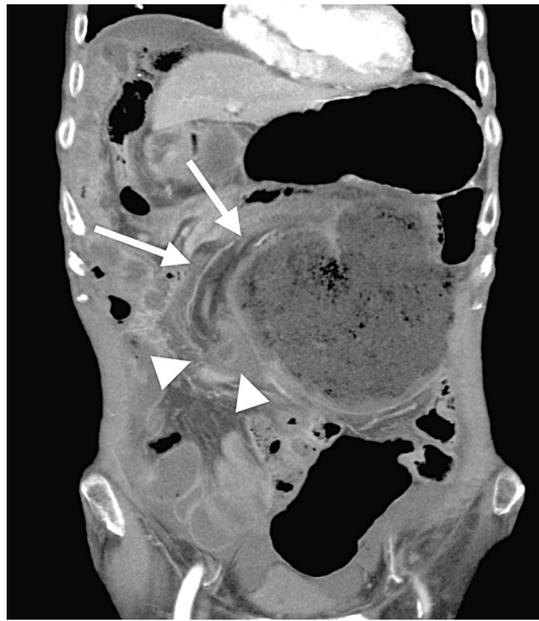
Coronal CT section shows a grossly dilated cecum with beaking (arrows) and swirling of mesenteric vessels (arrowheads) at its point of transition to the collapsed colon.
